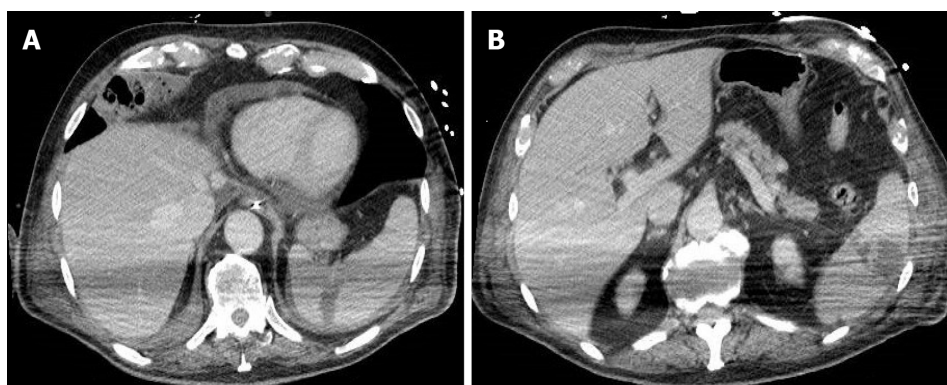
A 77-year-old man with abdominal tenderness. A: Contrast-enhanced portal-venous phase computed tomography image of the abdomen demonstrated a wedge-shaped low-attenuation area at the level of the spleen, typical of infarction. Pericardial effusion was also present; B: A further rounded low-attenuation area with peripheral localization was present in a lower portion of the spleen on contrast-enhanced portal-venous phase computed tomography scan.
